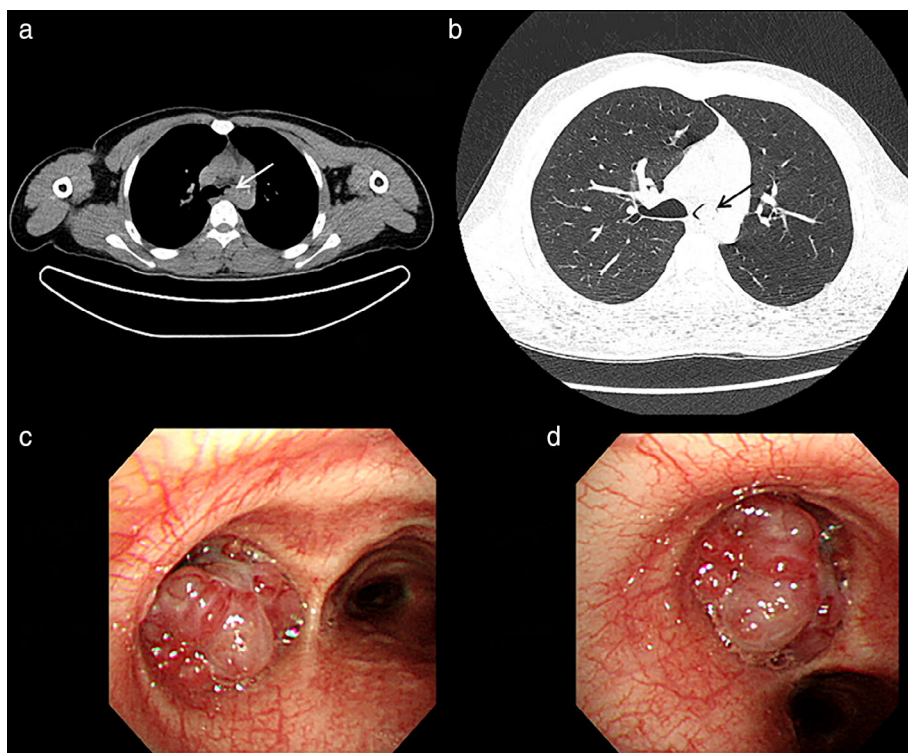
A computed tomography (CT) scan revealed a carcinoid causing obstruction of the left main bronchus (a, b, arrow designating tumor). The tumor was identified in the left main bronchus near the carina on bronchoscopy (c, d).
